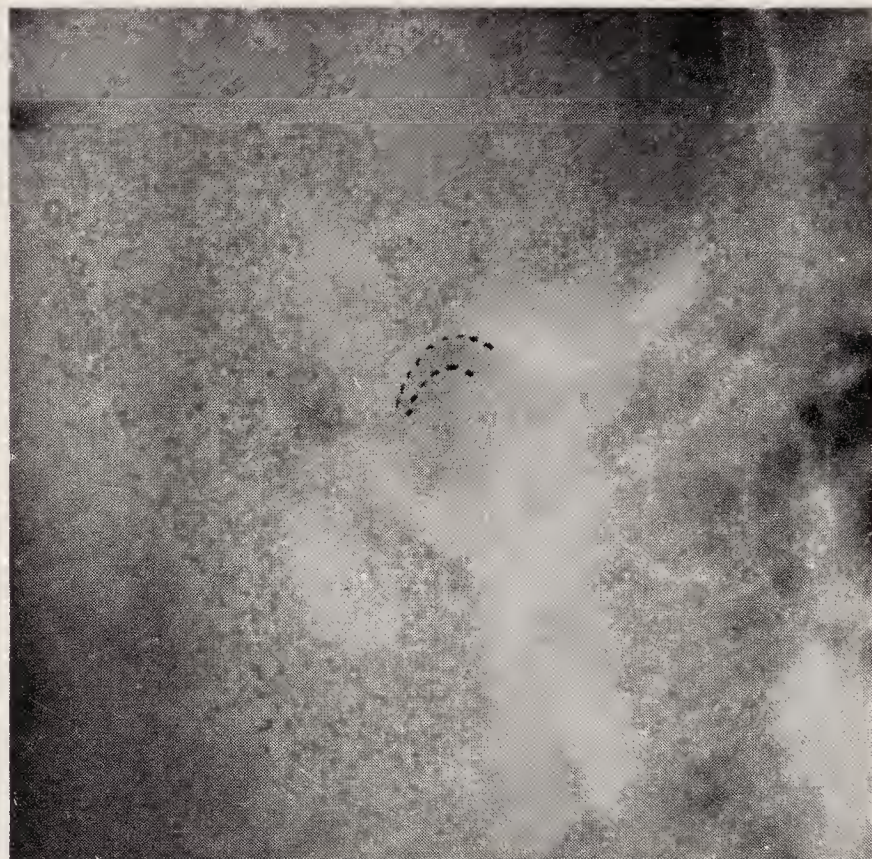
Radiograph of “reduced” joint space.
